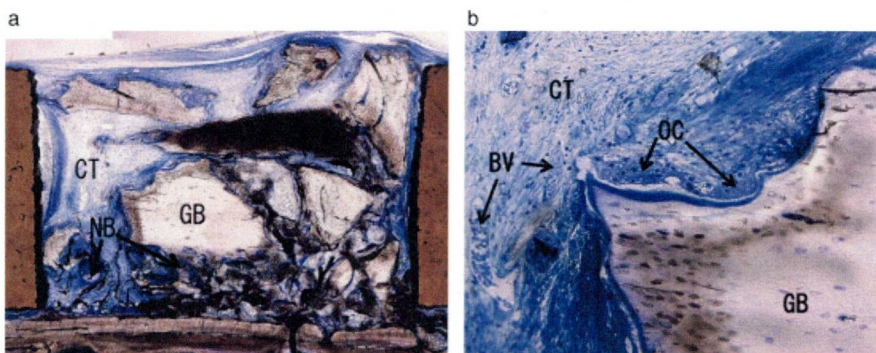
Large bone grafted site at 4 weeks. (a) The center of grafted bone (GB) retained its original form. Fibrous connective tissue (CT) was observed around GB. A large amount of new bone (NB) was formed from the host bone surface to the GB surface. Magnification $\times 2.5$. (b) High-magnification image of (a). Howship's lacunae with osteoclast-like cells (OC) were found at the surface of the GB. Fibrous connective tissue and blood vessels (BV) were observed around the GB. Magnification $\times 40$.
